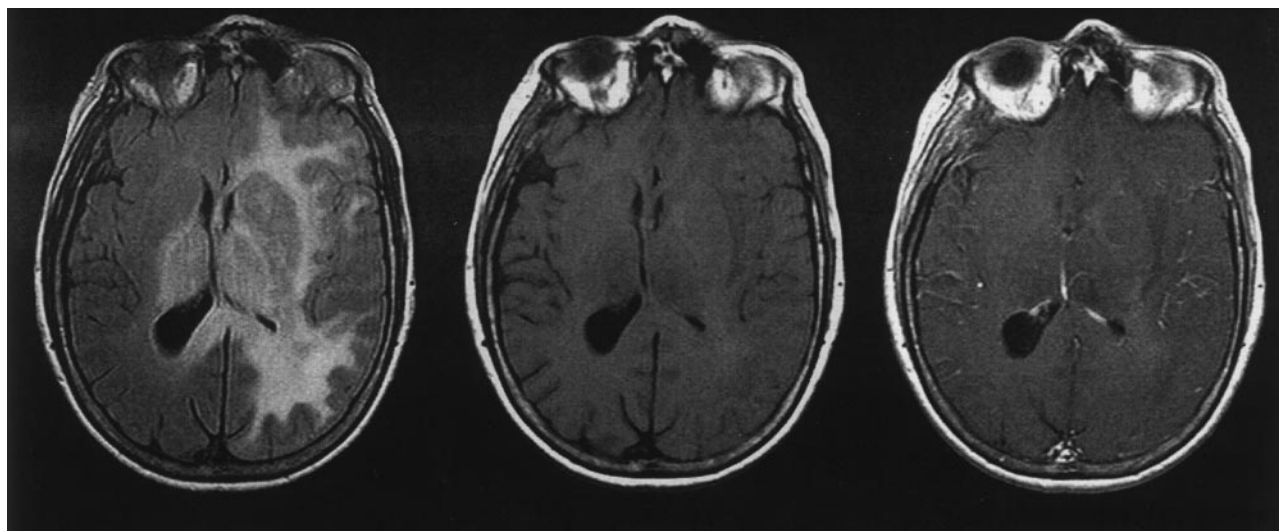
Spin-echo MR images. Axial view FLAIR image (left) shows extensive hyperintensity involving the left hemisphere white matter and basal ganglia, bilateral thalami, and splenium of corpus callosum, with mild mass effect. Comparison between unenhanced T1-weighted image (center) and contrast-enhanced T1-weighted image (right) reveals no appreciable enhancement.
